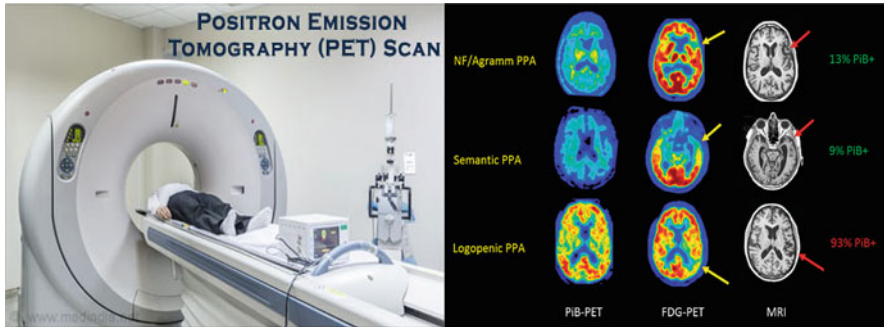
(a) PET scanner and (b) PET images along with MRI images. (Image source: <https://www.medindia.net/patients/patientinfo/positron-emission-tomography-scan.htm> and https://www.researchgate.net/figure/Changes-in-Brain-MRI-FDG-PET-and-PiB-PET-in-Three-Subtypes-of-PPA_fig_6_268802122)
